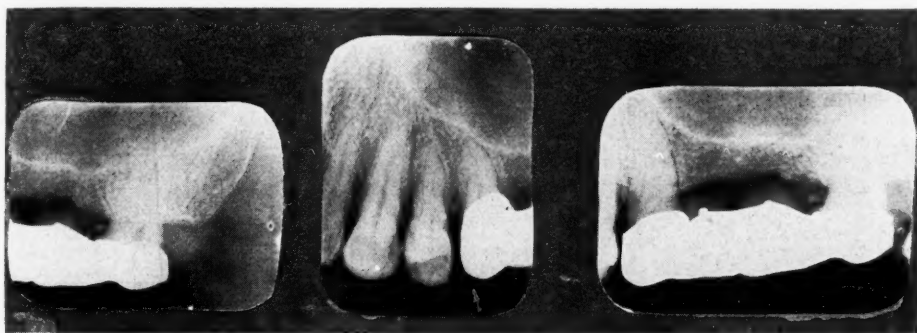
Intraoral roentgenograms showing region of right maxillary premolars and molars. In the maxillary second molar region is shown a definite bone change by an increase in the number of bone cells with a more or less regularity of size, and slight rarefaction especially of the ridge area. Pus was found in a small fistular opening in this region. An exploratory incision showed an area of chronic osteomyelitis extending into the maxillary sinus.
